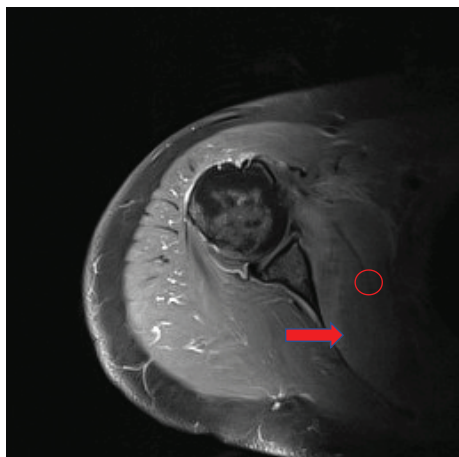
MRI of Rt. shoulder coronal T1 sequence demonstrating edematous subscapularis muscle.
